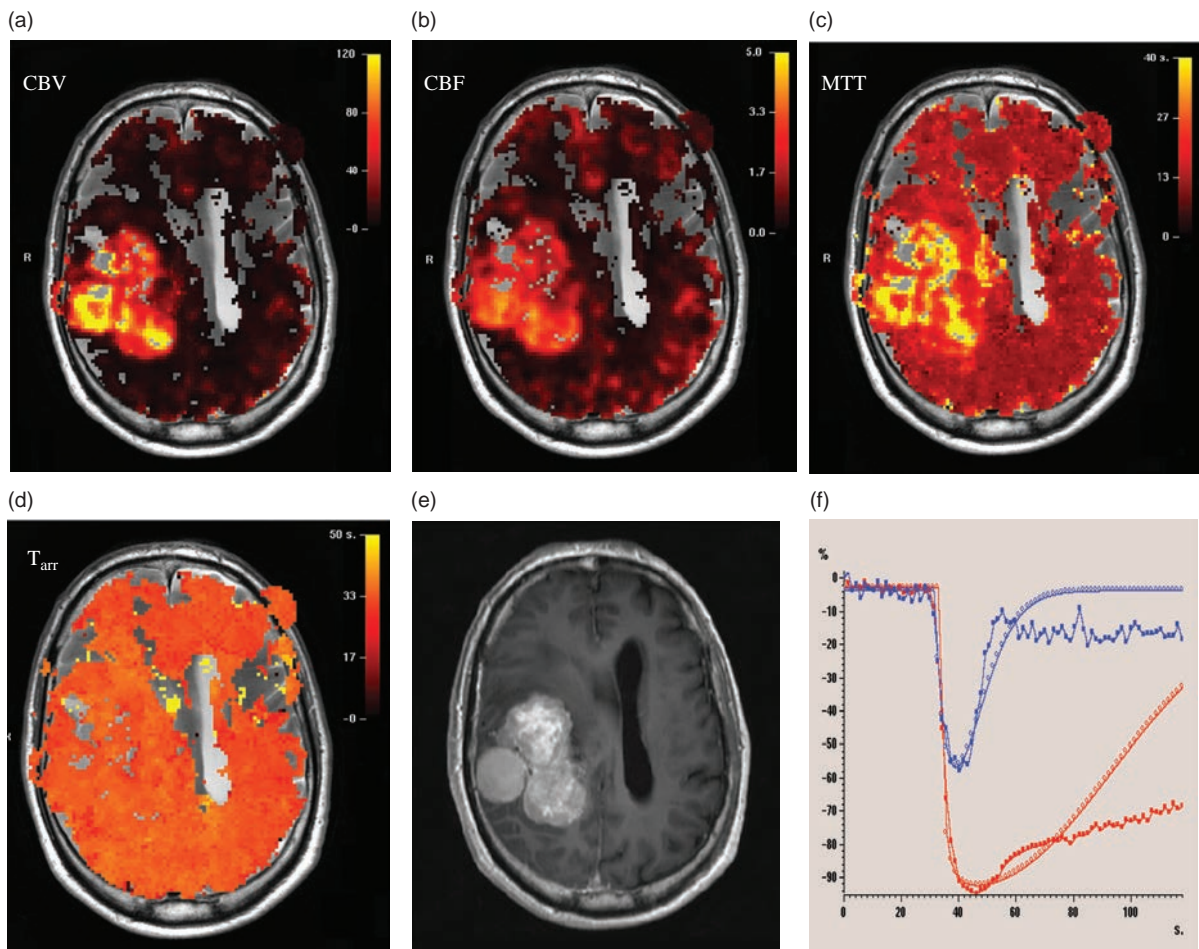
Perfusion parameter maps from DSC-MRI in a patient with a glioma. (a) CBV, (b) CBF, (c) MTT, (d) time of arrival (t_{arr}), (e) matching post-Gd T_1 -weighted image, (f) time-intensity curves for normal brain (blue) and tumour (red). Note how the fitted gamma-variate curve deviates from the real data due to rapid leakage of Gd into the tumour.
